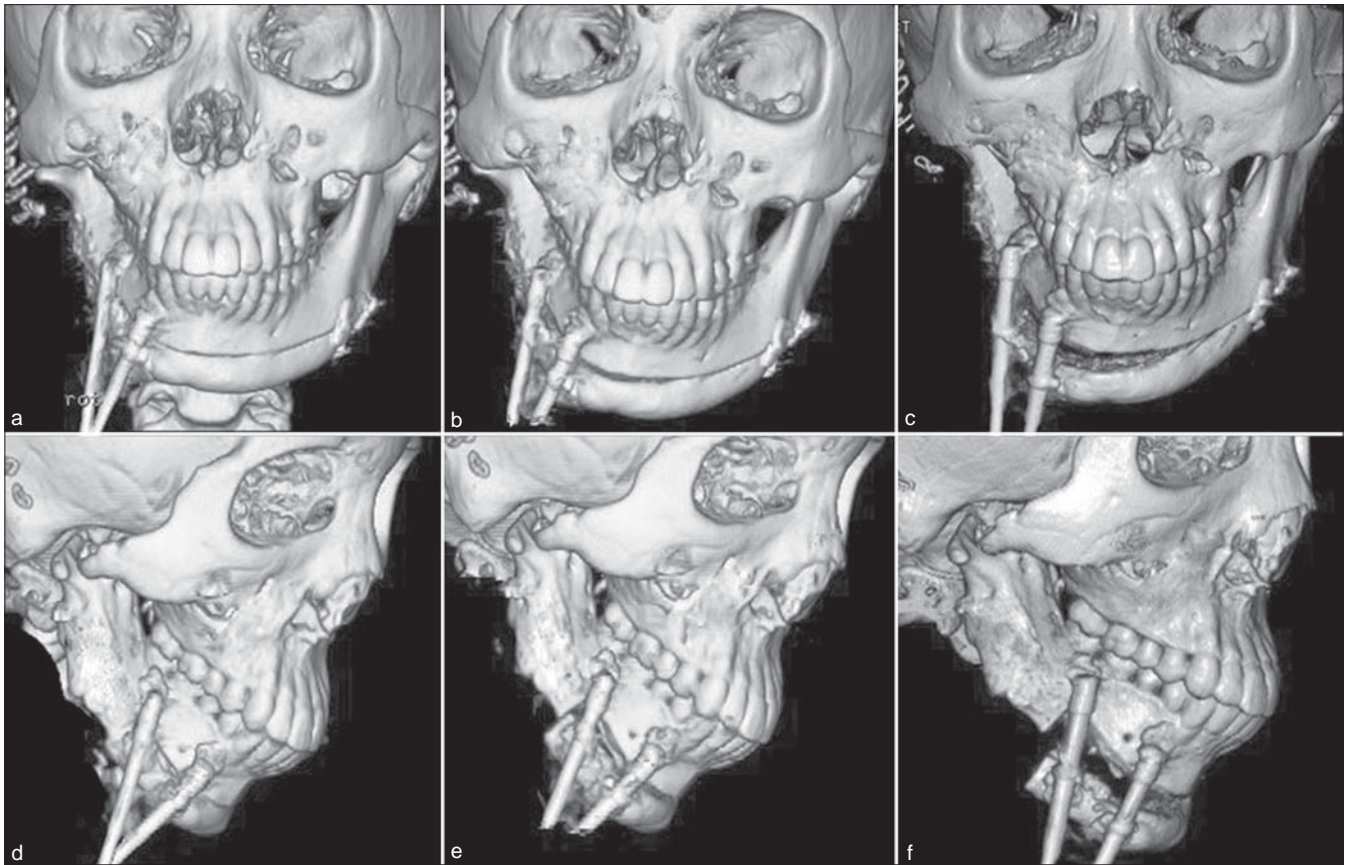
CT images during the distraction period. Note the altered crossing angle of two devices due to neck movement of NAVID system in three dimensions (a, b) Immediately prior to the distraction, (c,d,e) During distraction, (f) Immediately after distraction
